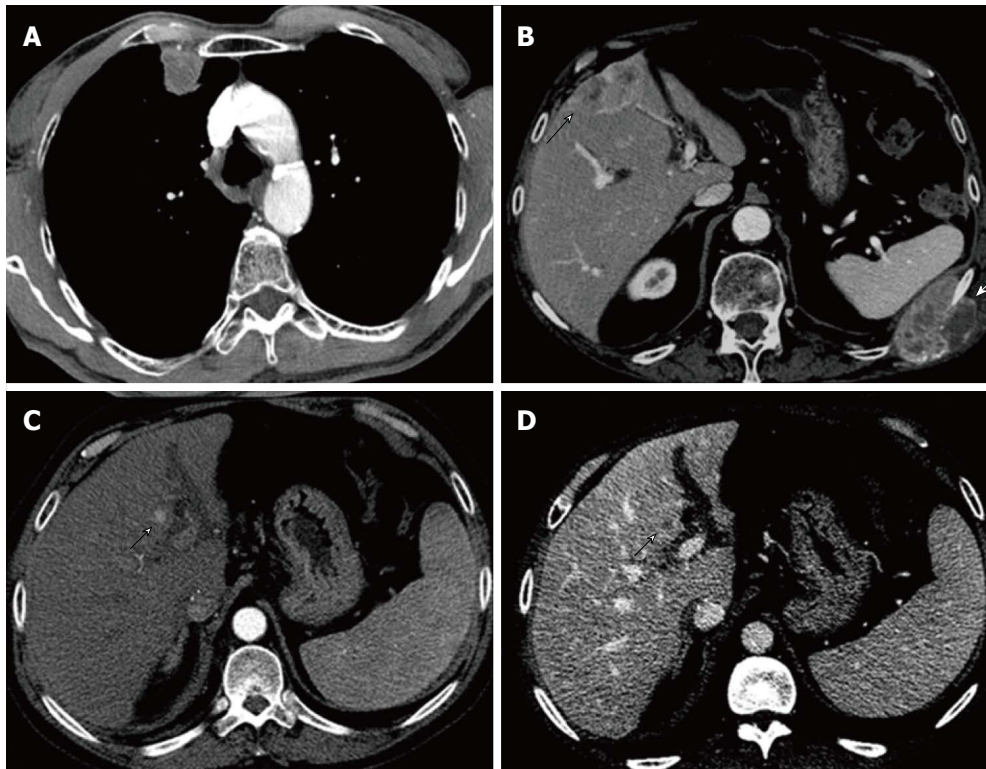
Representative multidetector CT images of different recurrence patterns based on the location at the moment of the first recurrence: (A) Extrahepatic recurrence presenting with a solitary pleural-based lung nodule; (B) Both intrahepatic and extrahepatic recurrence presenting with bone lesions and an intrahepatic lesion in segments IVb and V; (C and D) Intrahepatic recurrence presenting with a solitary hypervascular nodule in segment IV.
